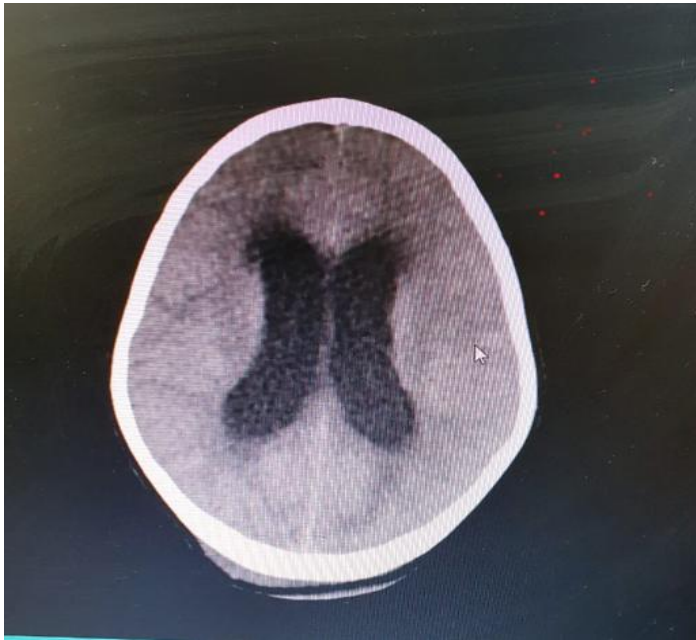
CT scan shows dilated ventricles due to hydrocephalus.
